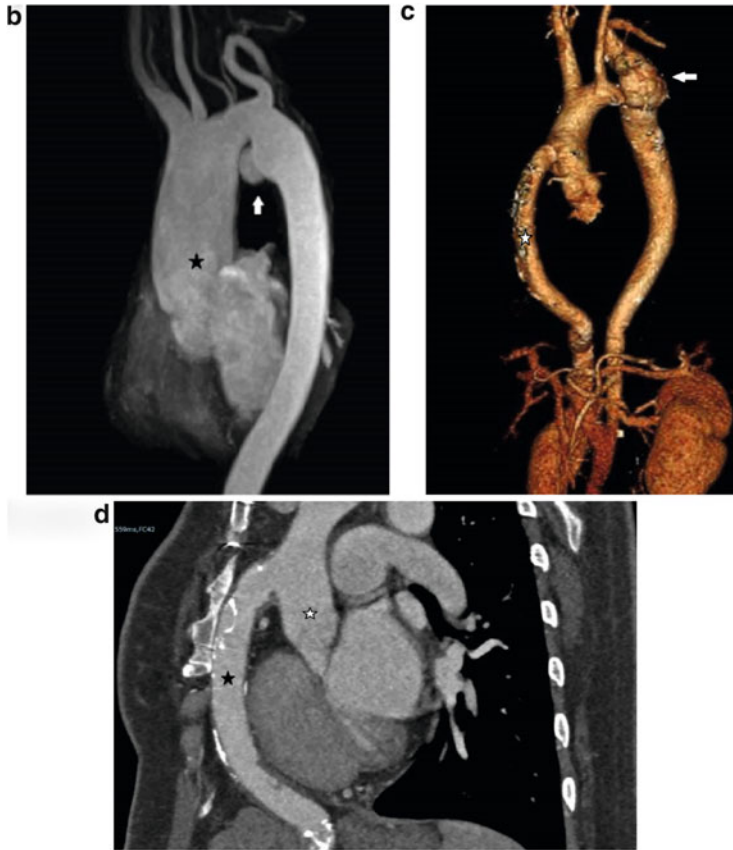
Coronal MPR CT image (b) in a post CoA repair patient showing a small aneurysm at the post repair site (*arrow* in b) and dilatation involving the SOV and ascending aorta (* in b). VRT (c) and coronal MPR (d) images from a different post CoA repair case show a large complex aneurysm at repair site in arch (*arrow* c) and a patent jump graft (* in d) from the ascending to abdominal aorta
